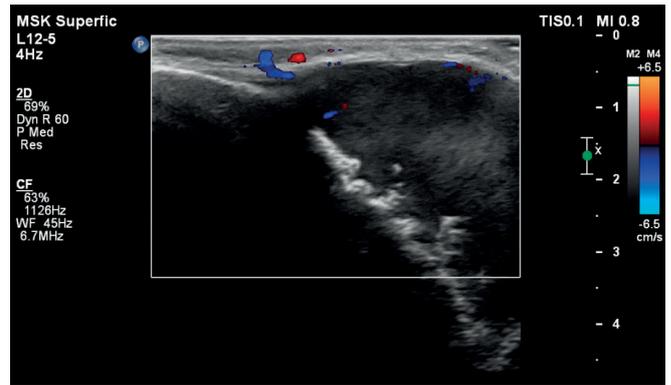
Ultrasonographic image of the lesion showing the changed cortical layer of the skull and the lack of significant vascularization of the lesion in the Color Doppler option
